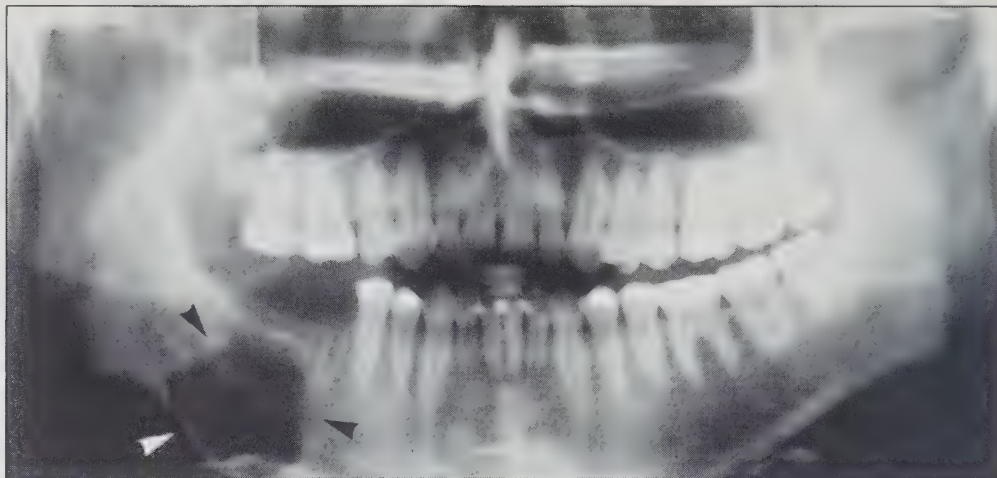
(Case 1): A 28-year-old male presented with an extensive ossifying fibroma. A panoramic radiograph exhibits a moderately well delineated unilocular radiolucency of the mandible that involved teeth 46 and 47 (black arrows). Note involvement of inferior border (white arrow). The teeth have been extracted and the oral mucosa has been primarily closed in order to facilitate a one-stage treatment plan.
